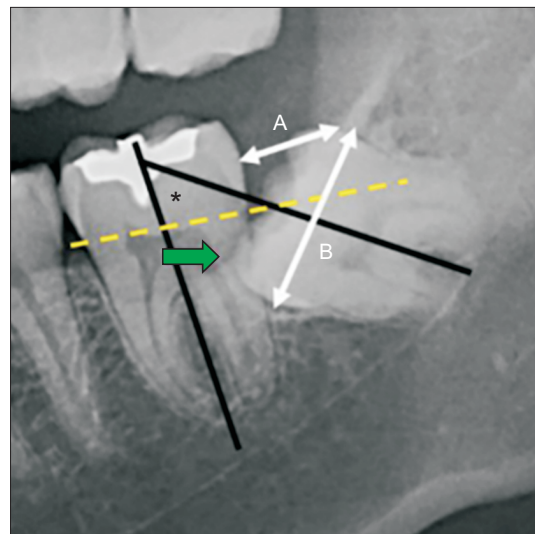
Measurement and classification of the impacted third molar in panoramic x-ray. The spatial relationship was classified on the basis of the angle measured between the long axis of the impacted third molar and that of the adjacent second molar (black lines and an asterisk mark). Depth was classified on the basis of the line connecting the cemento-enamel junction (CEJ) of the adjacent second molar (dotted yellow line). Ramus relationship/space available was subcategorized on the basis of the ratio between the distance from the ascending ramus to the distal of the second molar (A) and the diameter of the impacted third molar (B) (white arrows). Pathologic condition was identified as cuspal contact below the CEJ (green arrow).
